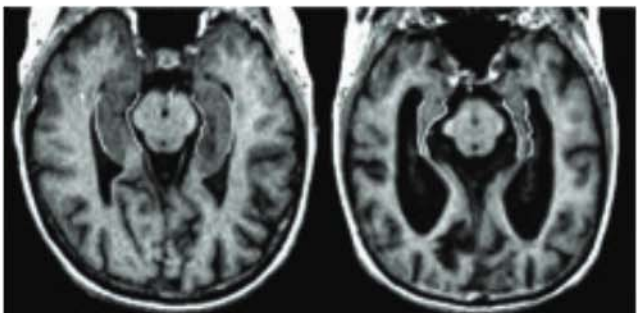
MRI images show the brain tissue of a person without Alzheimer's disease (left) and that of a person with the disease. Note the shrinkage in the brain on the right.
